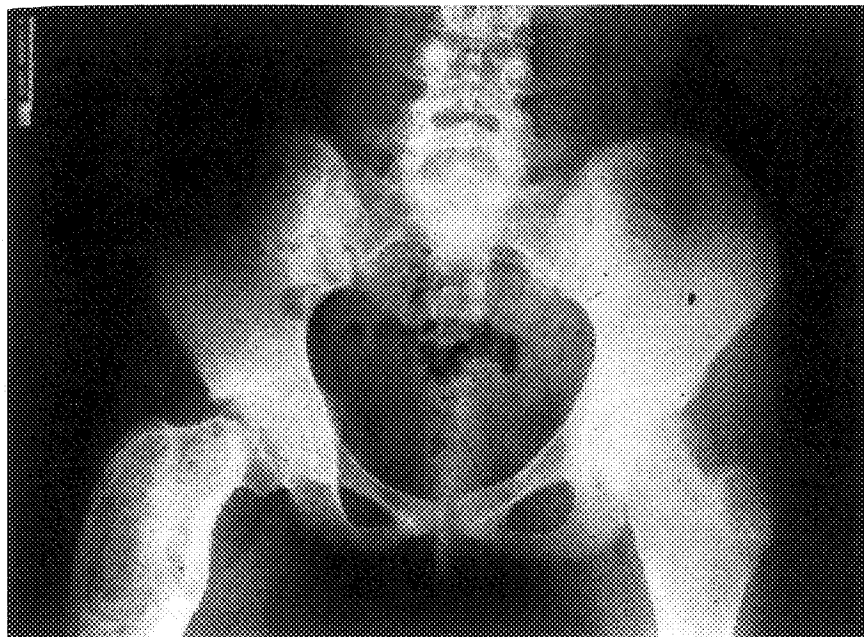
Typical X-ray appearance of fibrous dysplasia of bone involving both femoral necks in a 16-year-old girl.
